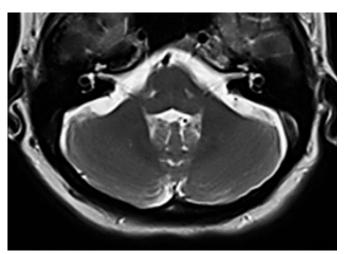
Patient's MRI brain T2 sequence showing mild cerebellar atrophy.
